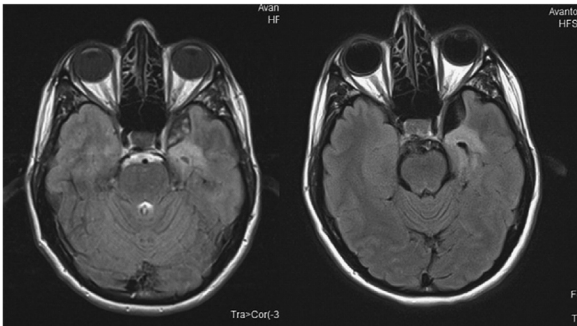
Axial T2 fluid attenuated inversion recovery (FLAIR) (left), Axial T2 FLAIR BLADE (right) images of the brain. The signal within the arachnoid cyst in the conventional image cannot be assessed accurately due to the image flow artifacts. In T2 FLAIR BLADE, these artifacts are reduced resulting in very good depiction of the pathology, which provides the possibility for more accurate measurements so that a potential pressure on the medial rectus muscle or internal carotid can be estimated.
